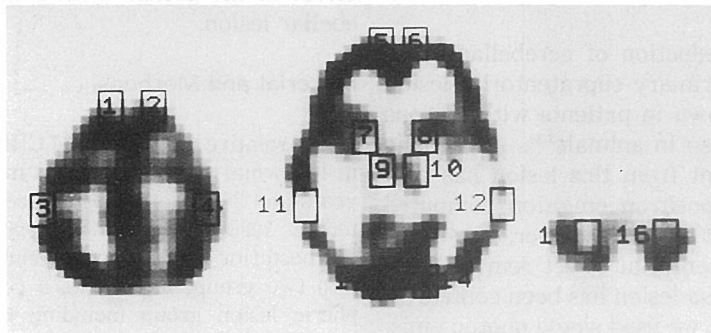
Regions of interest in ACA, MCA, PCA, territory, basal ganglia, thalamus and cerebellum as used for analysis of IMP SPECT
